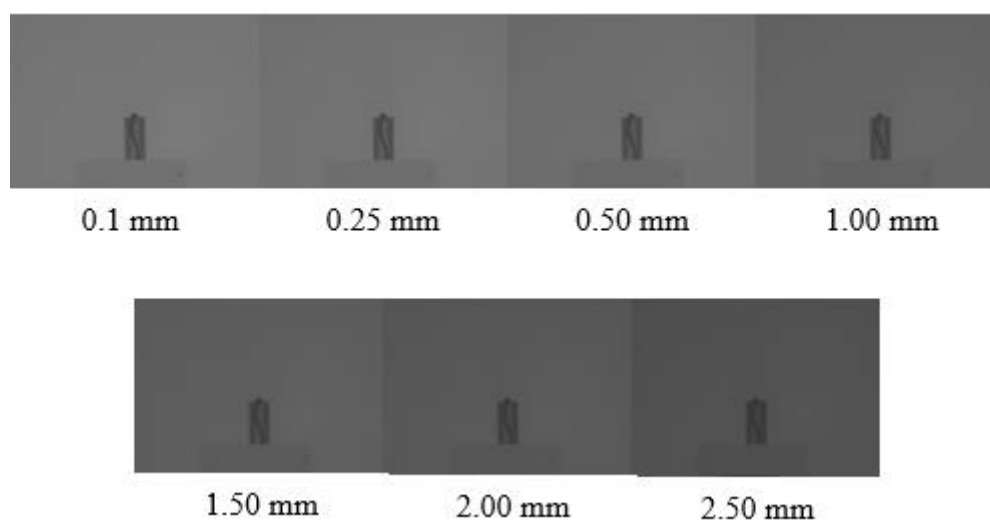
Typical radiographs that were acquired within the aluminium filter thickness range of 0.1 mm – 2.50 mm, X-ray current of 100 μ A, X-ray tube voltage of 100 kV, FSD 65 cm and X-ray exposure time of 1 sec.
